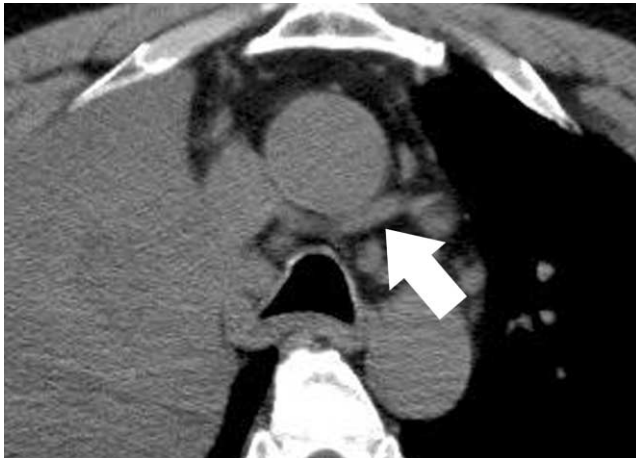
Non-enhancement CT scan shows that the posterior branch (arrow) mimics an enlarged lymph node.
